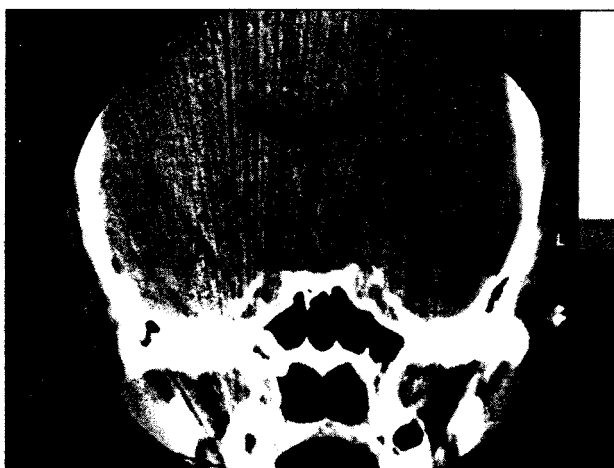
Brain CT (coronal) shows deeply implanted bitemporal subdural strip electrodes into the medial temporal lobe (Arrows indicate the tip of 4 contact electrodes near the posterior clinoid process).
